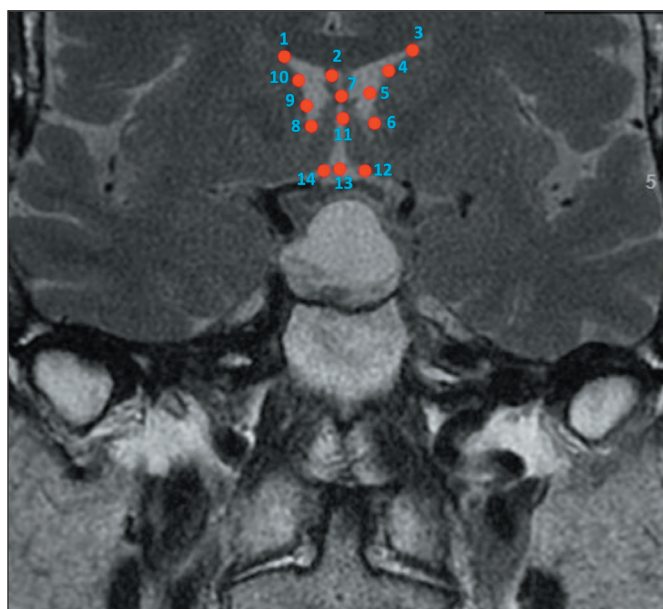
Landmark markings used for geometric morphometric analysis, targeting the sagittal plane of the ventricular system, including the third and lateral ventricles and their connection via the foramen of Monro, as visualized on coronal magnetic resonance imaging scans.
